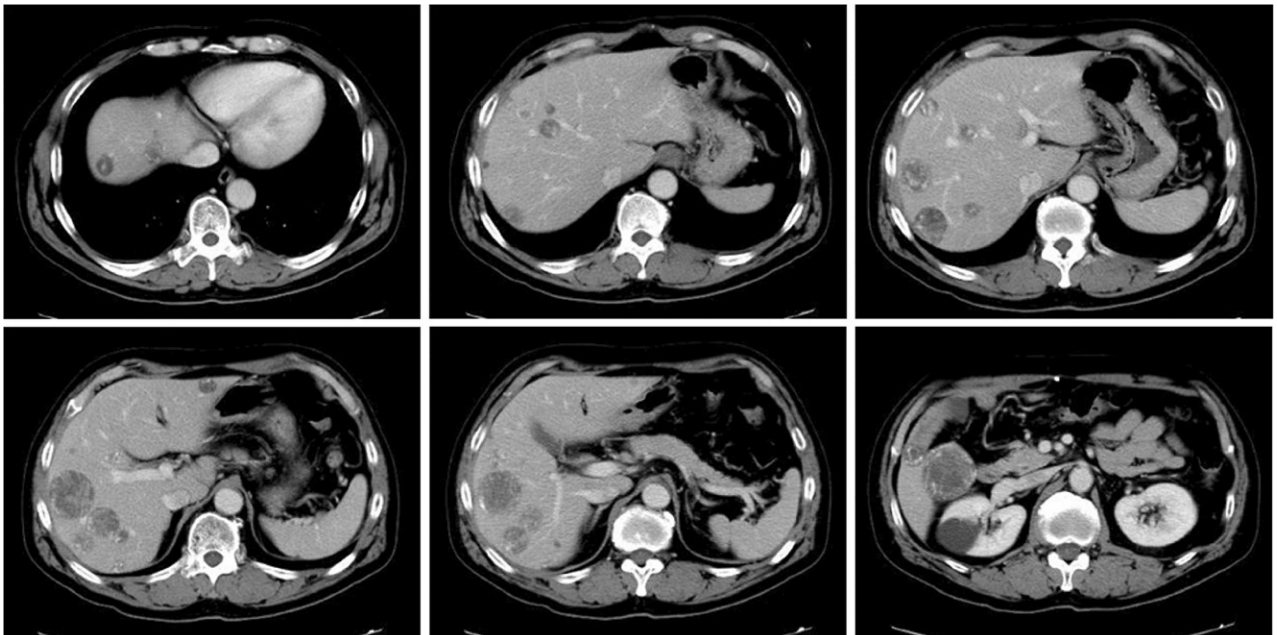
Abdominal computed tomography (CT) after 23 courses of FOLFOX-BV administration showed that the liver metastases had shrunk. Enhancement showed the tumors as isodense images instead of low-density images. FOLFOX-BV, 5-fluorouracil/leucovorin, oxaliplatin, plus bevacizumab.
